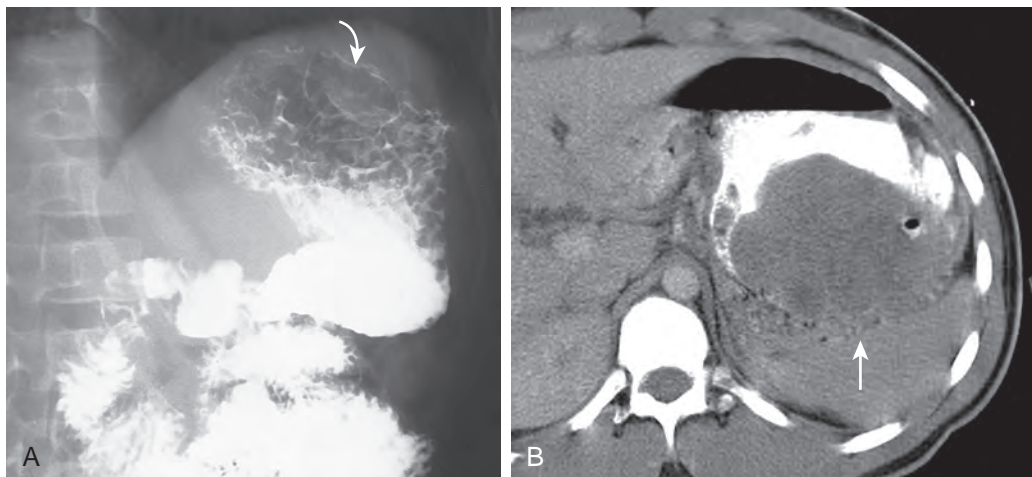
Gastrointestinal stromal tumor of stomach. A. The upper gastrointestinal series demonstrates a large filling defect (arrow) in the gastric fundus. B. CT scan shows the fundal, intraluminal soft tissue mass (arrow represents the tumor outlined by contrast material in the stomach).
